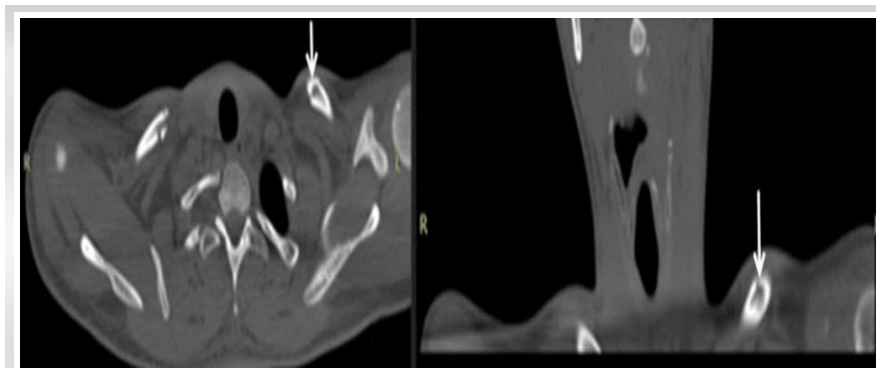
Axial and coronal computed tomography scans demonstrating a non-displaced fracture of the midshaft of the left clavicle.
